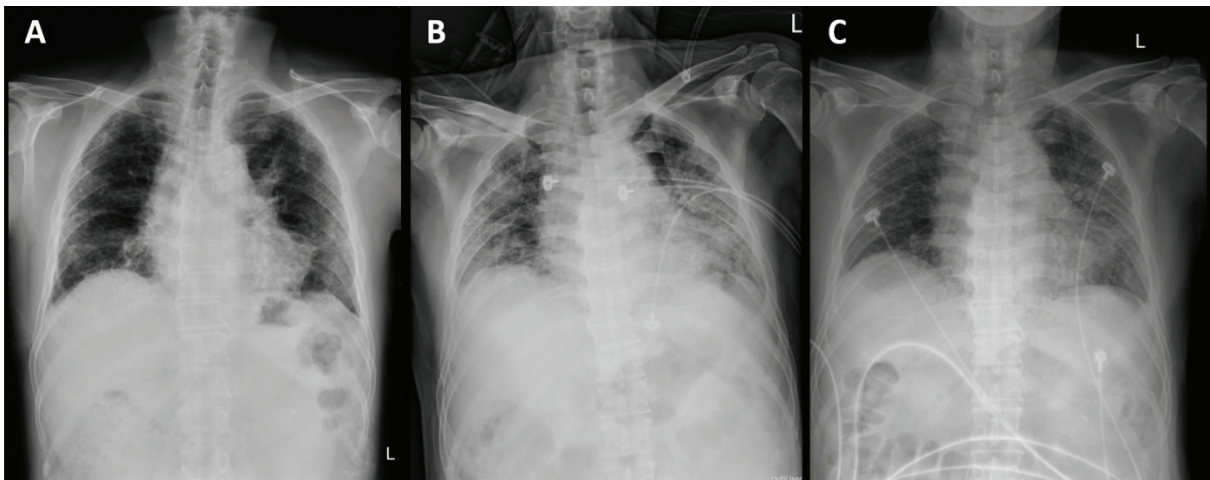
Chest radiograph at (A) Four months previous, as baseline. (B) Initial presentation of acute exacerbation. (C) Three days after tocilizumab use. In a 60-year-old man, (A) Baseline peripheral reticulation and an apical-basal gradient pattern of fibrosis was seen on chest radiograph 4 months ago. Note the left upper lung tumor is not prominent on the plain film. (B) Increased bilateral interstitial infiltration and ground-glass opacity was seen on chest radiograph when he presented to the emergency room for severe COVID-19 and superimposed AE-IPF. (C) Partial resolution of bilateral ground-glass opacity was found 3 days after tocilizumab therapy.
